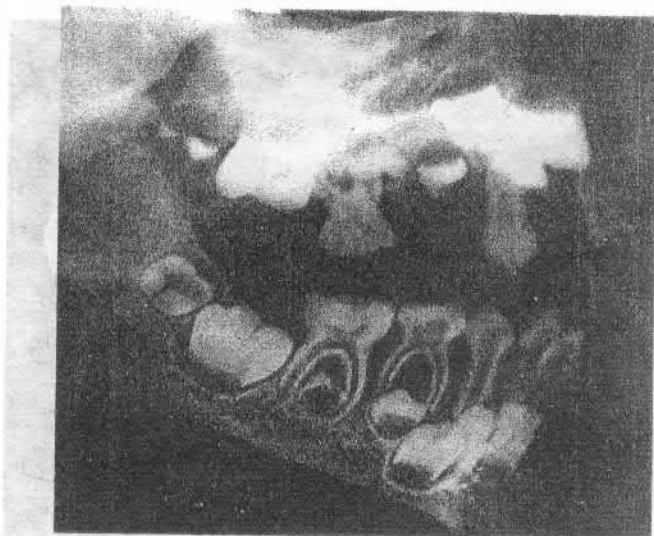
Radiography of maxillaries at the age of 1 year
